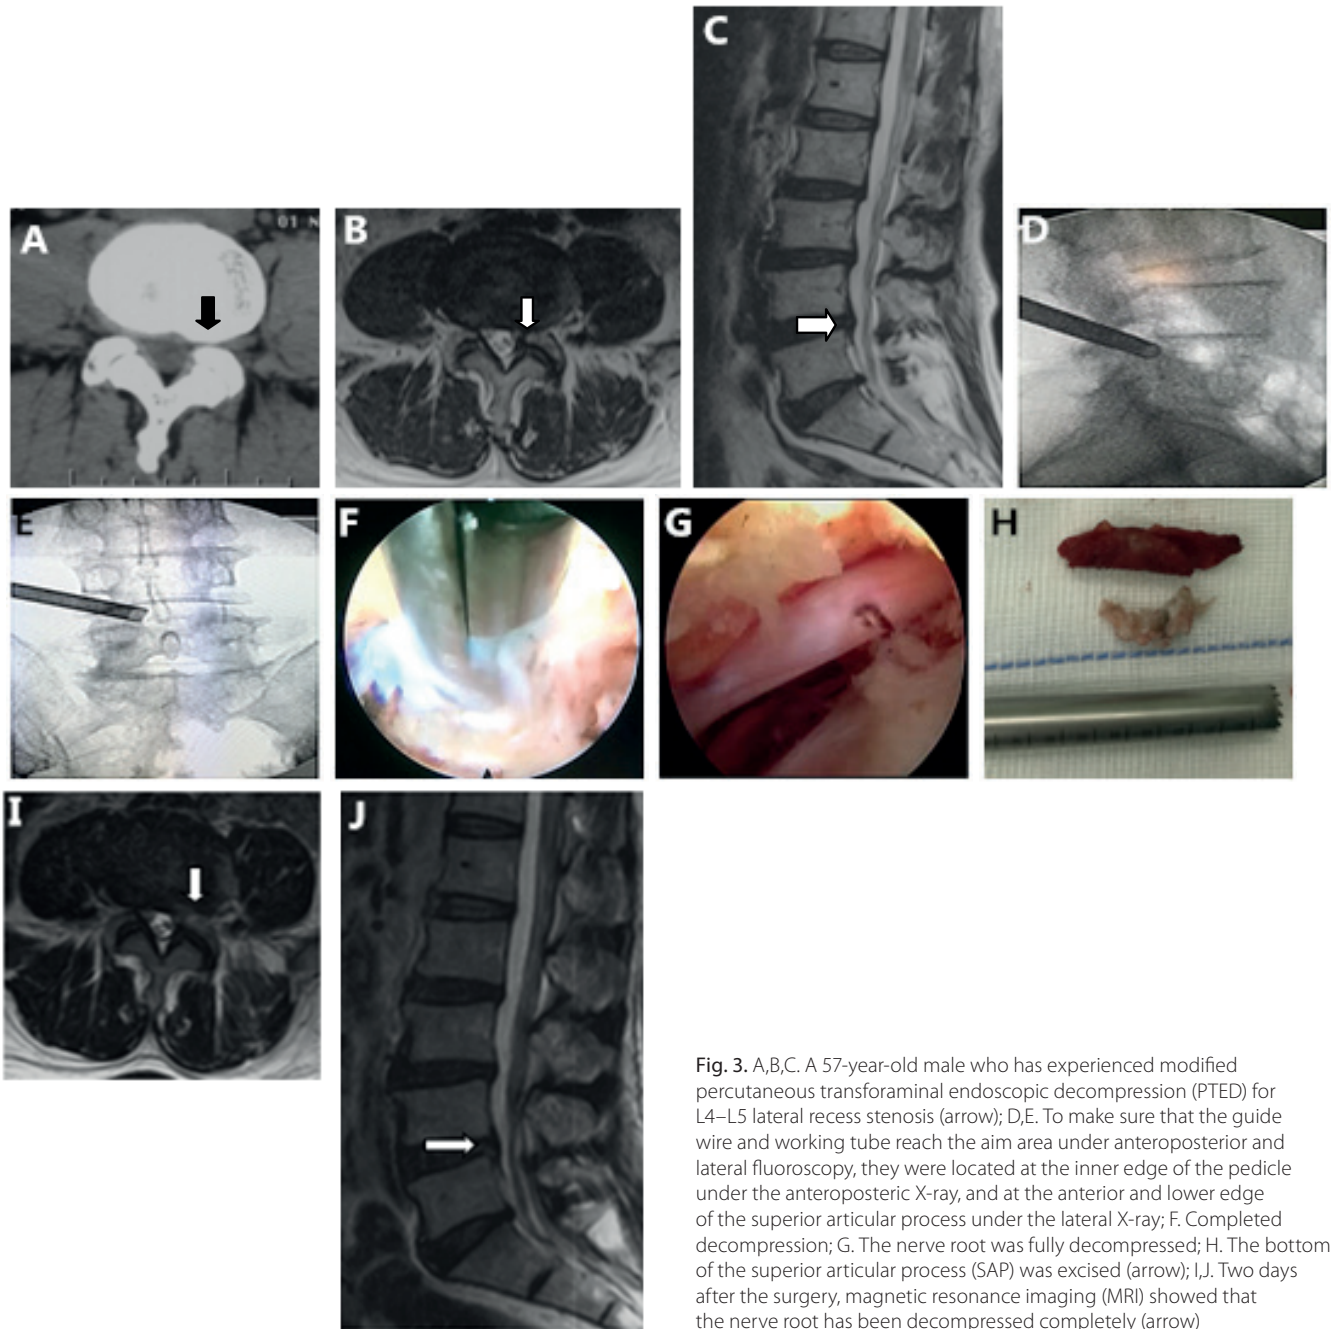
A,B,C. A 57-year-old male who has experienced modified percutaneous transforaminal endoscopic decompression (PTED) for L4–L5 lateral recess stenosis (arrow); D,E. To make sure that the guide wire and working tube reach the aim area under anteroposterior and lateral fluoroscopy, they were located at the inner edge of the pedicle under the anteroposteric X-ray, and at the anterior and lower edge of the superior articular process under the lateral X-ray; F. Completed decompression; G. The nerve root was fully decompressed; H. The bottom of the superior articular process (SAP) was excised (arrow); I,J. Two days after the surgery, magnetic resonance imaging (MRI) showed that the nerve root has been decompressed completely (arrow)
